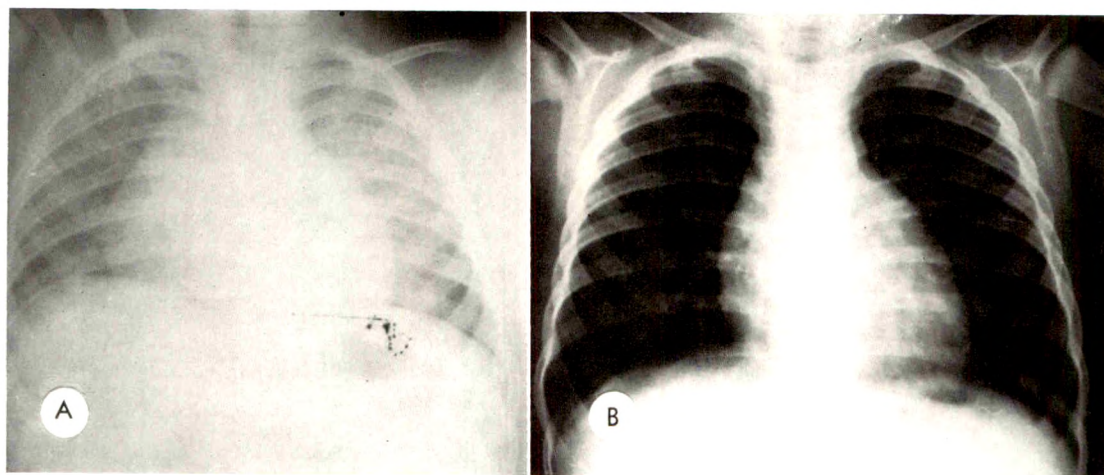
(A) Expiration chest roentgenogram. (B) Inspiration chest roentgenogram of the same patient, made the same day.
